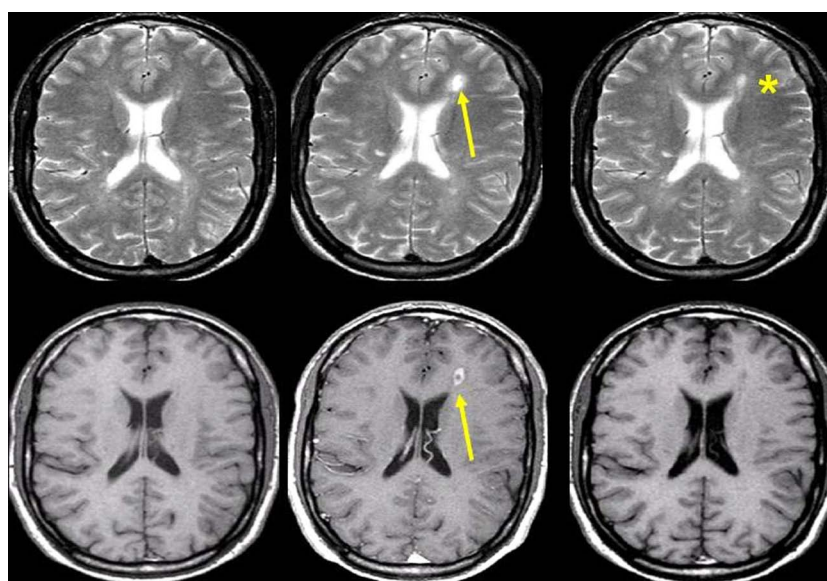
Transverse T2-weighted (upper row) and contrast-enhanced T1-weighted (lower row) brain magnetic resonance imaging scans obtained serially at monthly intervals in a patient with multiple sclerosis. Observe formation of a new plaque in the left frontal white matter showing transient contrast uptake (arrow). With cessation of inflammatory activity, the T2 lesion decreased in size, but left a persistent hyperintense footprint on the T2-weighted image (asterisk).
